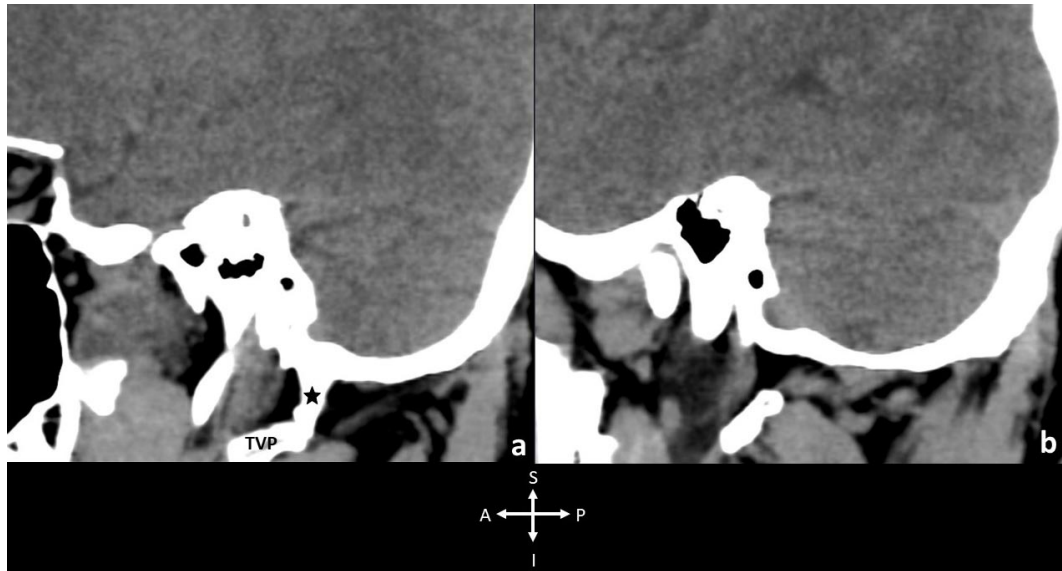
Shows sagittal computed tomography images of the left (a) and right (b) sides. (a) Star (black) indicates the paracondylar process. TVP, transverse process of the atlas. A: Anterior, P: Posterior, S: Superior, I: Inferior.
